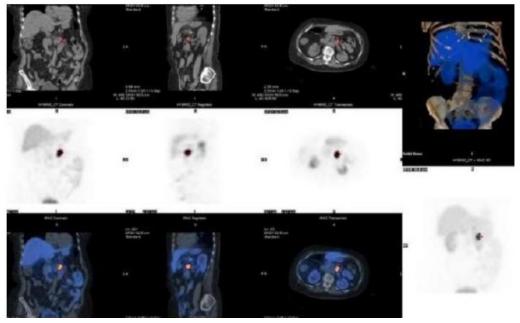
Local recurrence after caudal spleno-pancreatectomy of a G1 pNET for a patient with high serotonin levels and negative (inconclusive) CT exam. Somatostatin receptor scintigraphy (SRS): SPECT-CT acquisition at 2 hours after injection of radiolabeled somatostatin analogue (^{99m}Tc-Tekrotyd) (courtesy of Dr. Mirela Gherghe).
